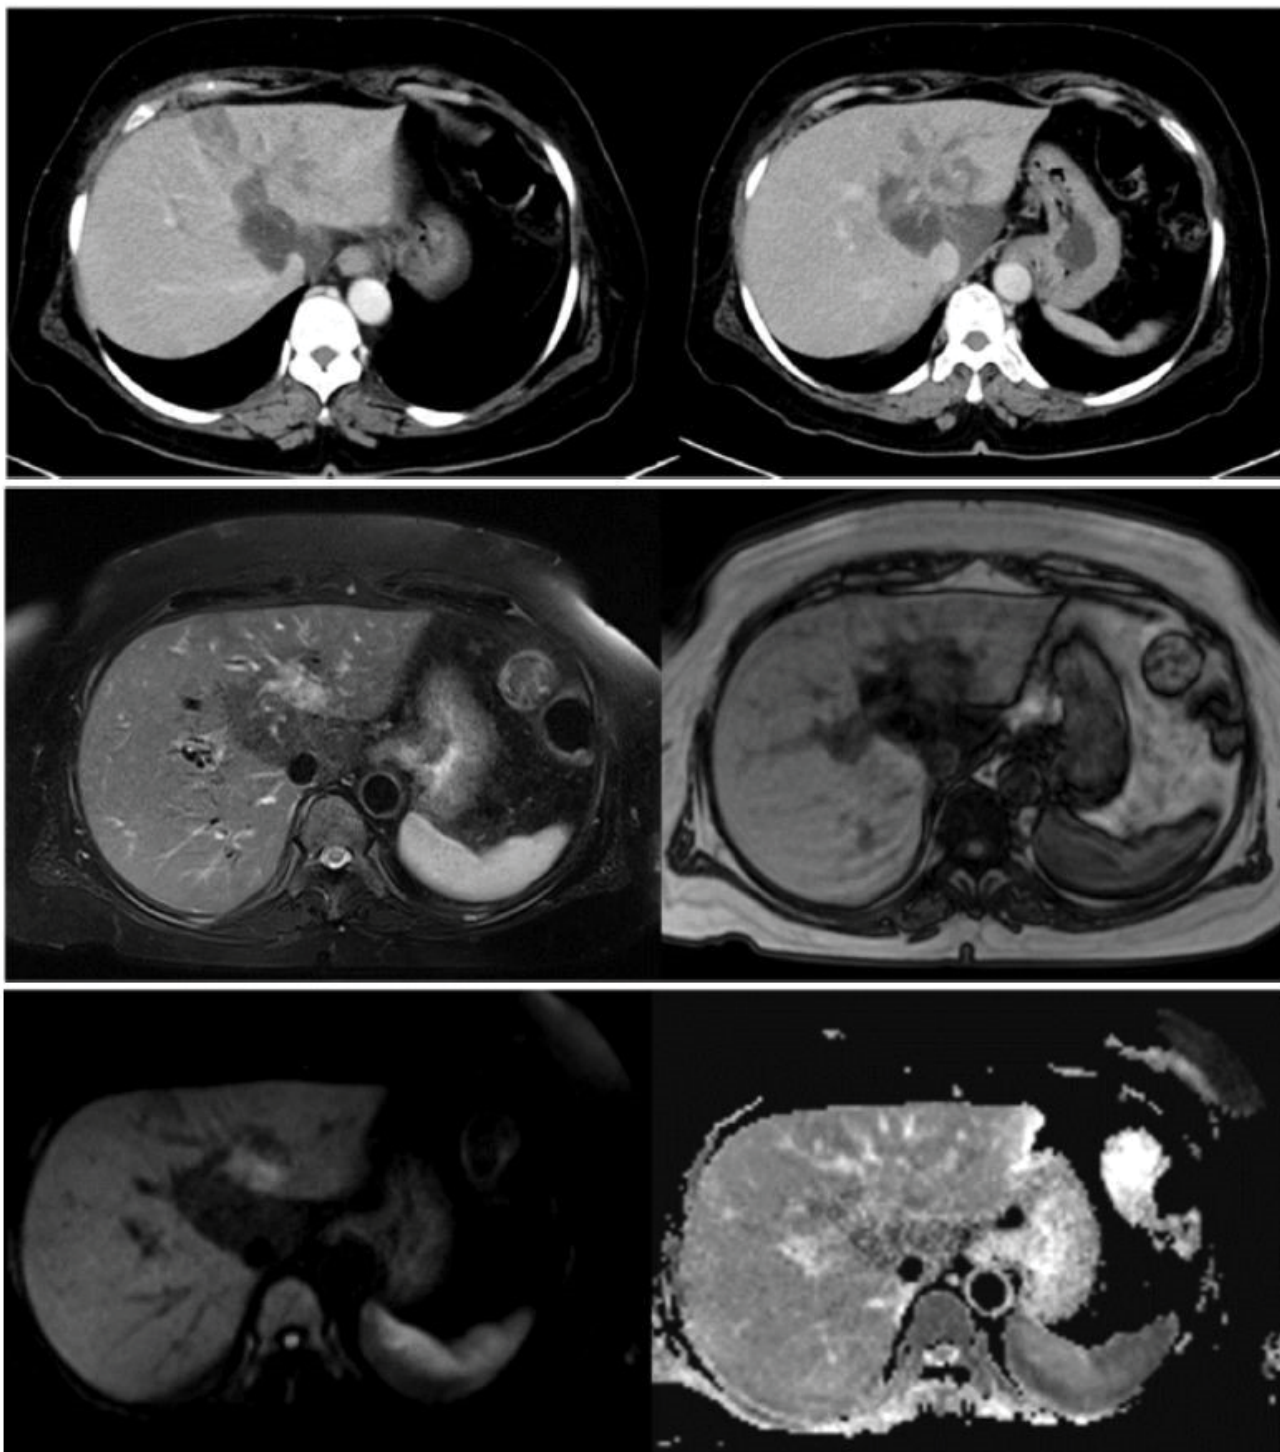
Inflammatory pseudotumor. (a,b) CECT axial sections show an ill-defined heterogeneously hypo-enhancing lesion seen involving the medial aspects of segments 2/3 with upstream biliary radicle dilatation in the segments 2 & 3. Geographic fat attenuating area involving caudate lobe and segment 4 of liver; (c,d) MRI T2 FS (a) and T1 out of phase (b) axial sections shows ill defined T2 FS hyperintense and T1 hypointense lesion in the medial aspects of segments 2/3 of liver; (e,f) MRI DWI (e) and ADC (f) axial sections shows ill-defined lesion that appears hyperintense and isointense in the diffusion weighted and ADC images respectively, suggestive diffusion shine through.
